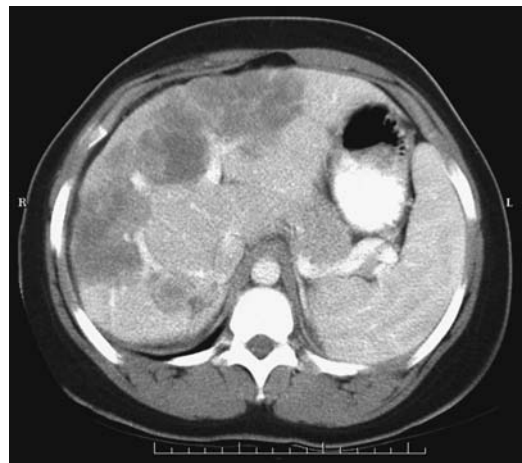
Epithelioid hemangioendothelioma in an 18-year-old woman. Contrast-enhanced CT reveals a large heterogeneous, lobulated tumor involving both right and left lobes. Some of the vessels coursing into it are attenuated. She underwent liver transplantation. (Courtesy of Patrick Fultz, M.D., University of Rochester.)
